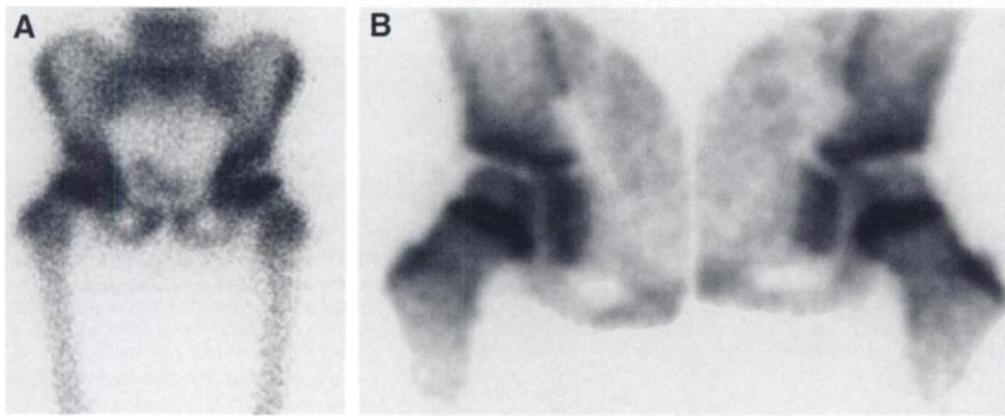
Transient synovitis with tamponade. (A) Anterior high-resolution planar imaging of a 4-yr-old girl with a left hip effusion shows asymmetrically decreased to absent tracer localization in the left femoral capital epiphysis. (B) Pinhole imaging reveals that tracer localization in the left femoral capital epiphysis is decreased relative to the normal degree of uptake demonstrated contralaterally. Reprinted with permission from Connolly LP, Treves ST, Connolly SA, et al. Pediatric skeletal scintigraphy: applications of pinhole magnification. *Radiographics* 1998;18:341-351.
